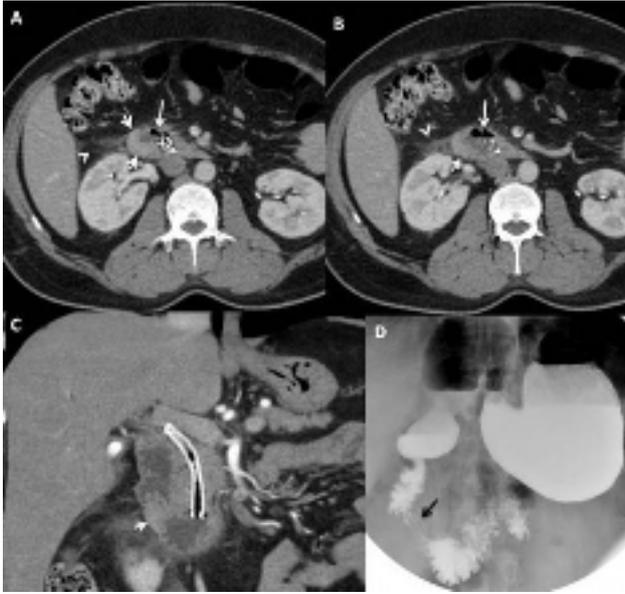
Contrast enhanced CT consecutive axial (A, B) and coronal images (C) shows 2nd part of duodenum (A, B, long arrows) completely surrounded by pancreatic tissue (A,B, C, small arrows) consistent with annular pancreas causing peripancreatic str
